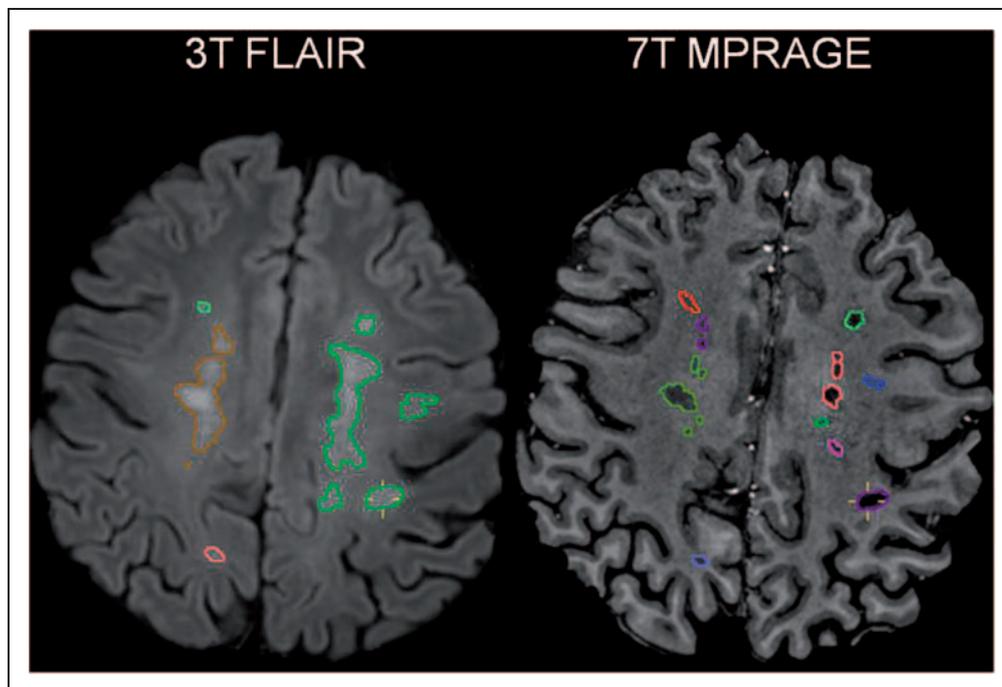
Differences in lesion counting when using MPRAGE and FLAIR images. On FLAIR images neighbouring lesions appeared as confluent hyperintense regions. On MPRAGE images the corresponding lesions appeared as more numerous discrete hypointensities. FLAIR: fluid attenuation inversion recovery, MPRAGE: magnetization prepared rapid acquisition gradient echo.
